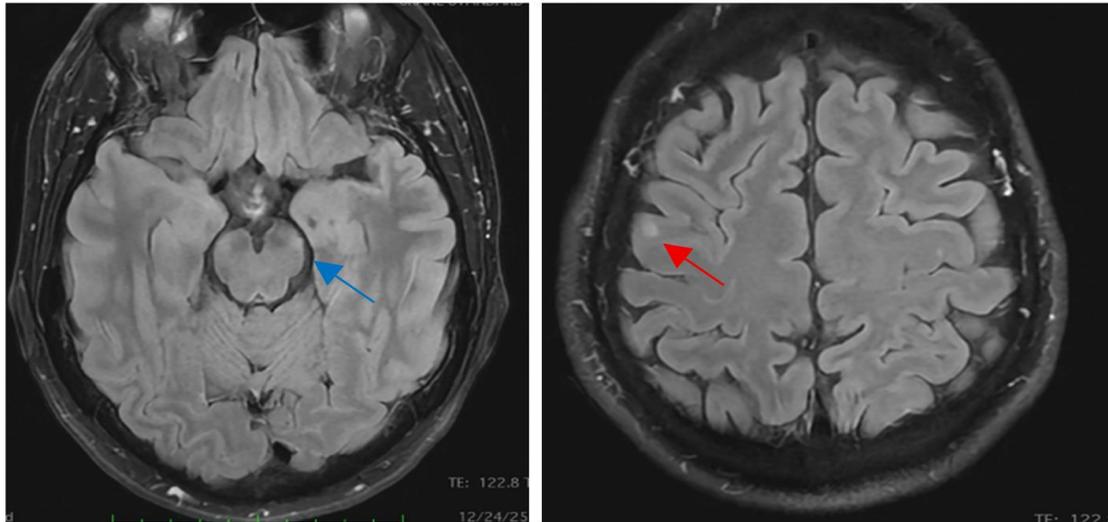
Brain MRI showing lesions located in the right juxtacortical region (red arrow) and in the left mesencephalic sulcus (blue arrow)
